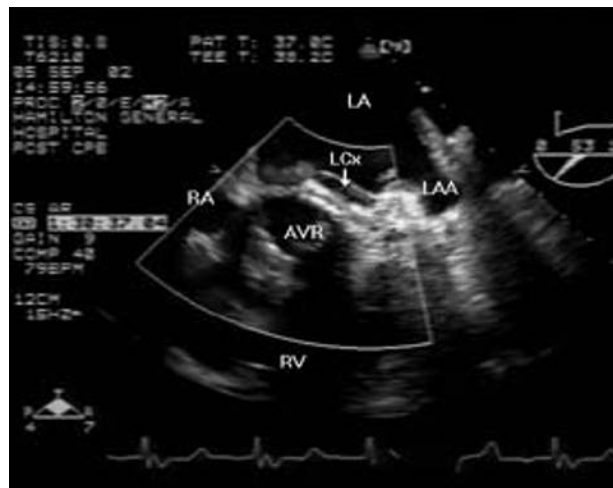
Post-AVR transesophageal echocardiogram image of the anomalous left circumflex artery (LCx), showing colour flow Doppler in the vessel. Left atrium (LA), right atrium (RA), left atrial appendage (LAA), right ventricle (RV), aortic valve replacement (AVR).
